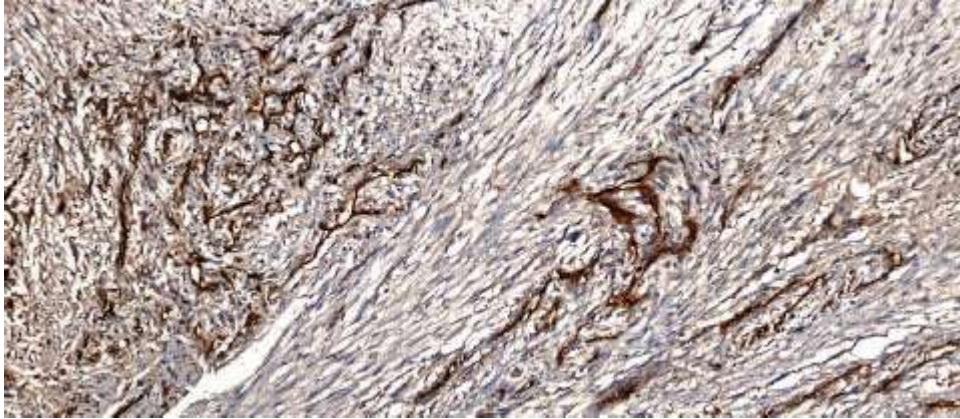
GB with sarcomatoid features showing membranous expression of PSMA of the endothelial lined vascular spaces. Original magnification power 200x.
